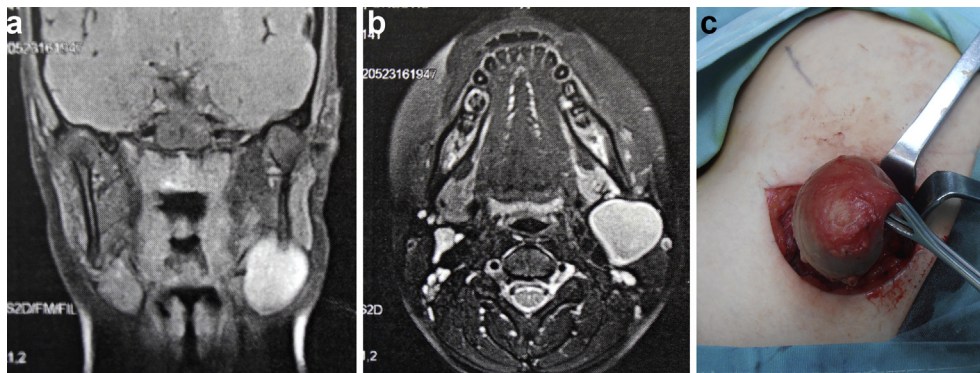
Branchial cyst in a 14-year-old male. a: CT imaging presentation – frontal plane. b: CT imaging presentation – horizontal plane. c: Perioperative presentation of branchial cyst removal.
